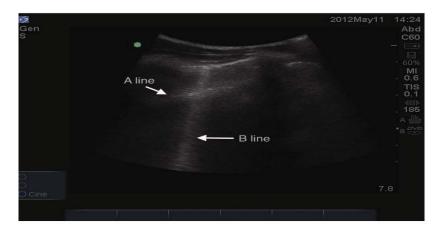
Lung ultrasound showing A and B lines in the same ultrasound field.
